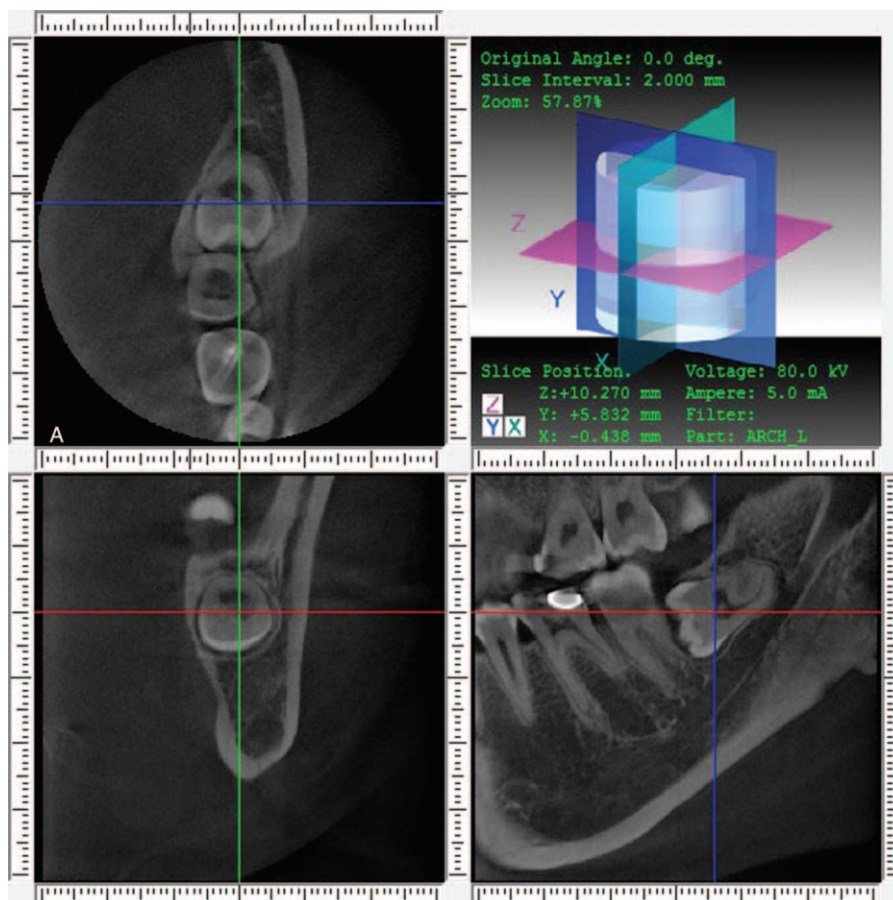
Cone-beam computed tomography (CBCT) image of axial view, paraxial view, and sagittal view of a lingual positioned fully impacted mandibular 3rd molar.
